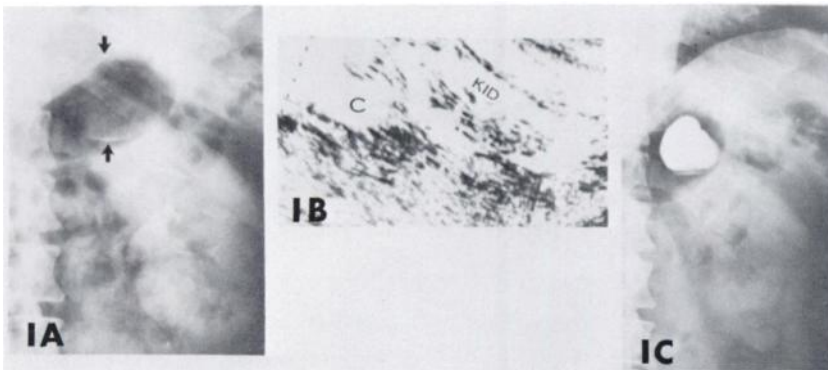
(A) Excretory urogram shows peripherally calcified mass (arrows) overlying upper pole of left kidney, (B) Prone longitudinal sonogram showing 3 cm cystic mass (c) adjacent, but separate from anteromedial aspect of the upper pole of left kidney (k), (C) Radiograph following contrast injection into adrenal cyst lumen.
